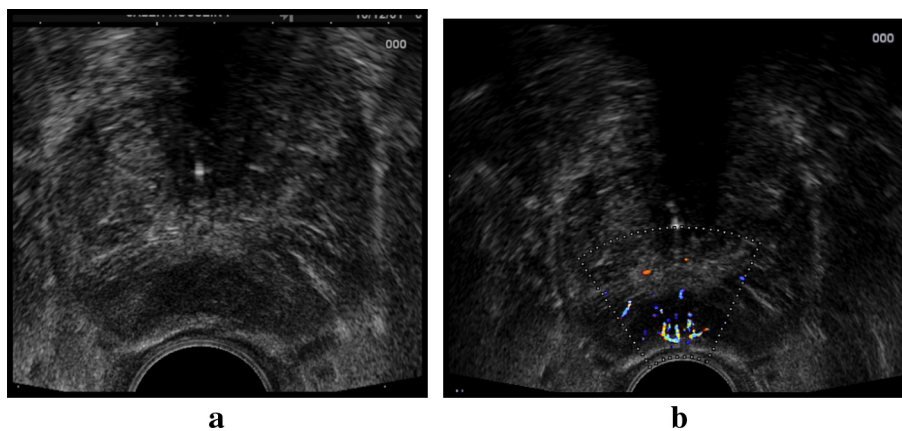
(a) Transrectal ultrasound B-mode image shows the loss of normal architecture of the peripheral zone with an ill defined hypoechoic focal lesion in a 68-year-old male presented with prostatic enlargement symptoms, elevated PSA level (35 ng/mL) with enlarged hard prostate consistency by PR examination. (b) In color Doppler, it appears hypervascular.
